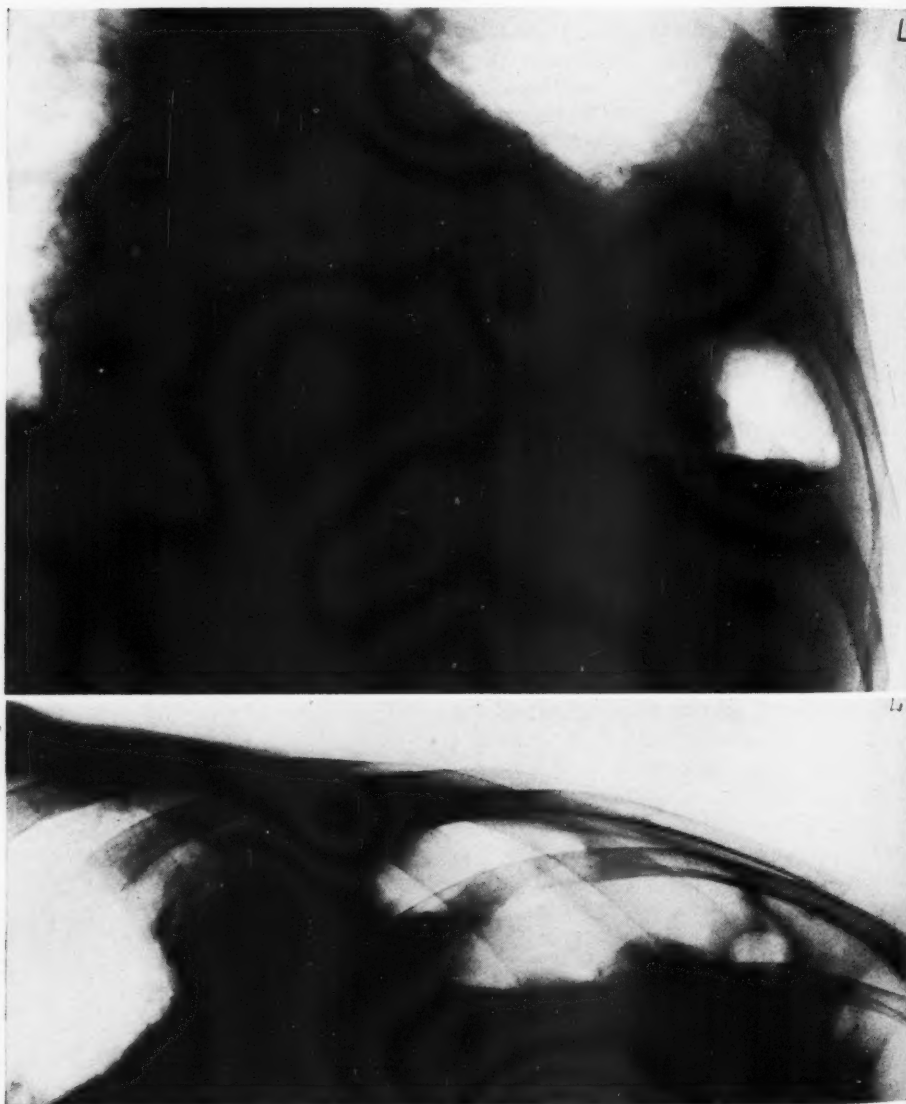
Case 1. Subphrenic abscess. An anteroposterior roentgenogram taken with the patient lying on his back, with the hips slightly elevated. Notice that the barium in the stomach did not reach the left diaphragm. This shows that something existed between the stomach wall and the diaphragm. There were numerous blood clots in the stomach so that many less dense shadows could be seen throughout the barium.
